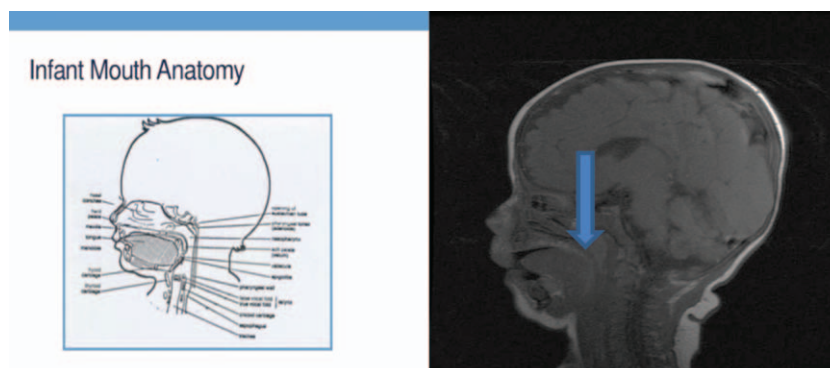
(A) Depicts a proper position of the oral cavity in infants;^[15] (B) Shows an MRI cerebral image of 2.5-month-old baby with the tongue shifted back (arrow).
